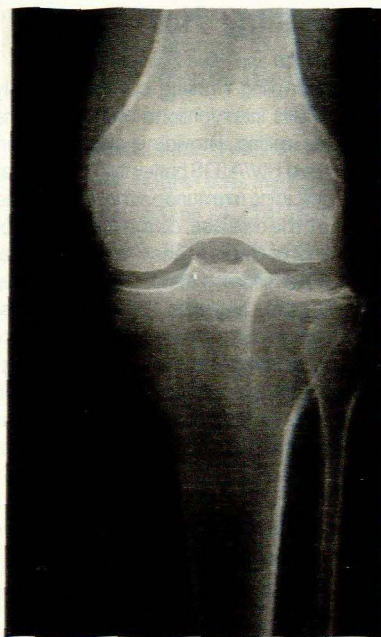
Radiograph of the left knee showing a lytic lesion involving the lateral aspect of the tibial plateau.
